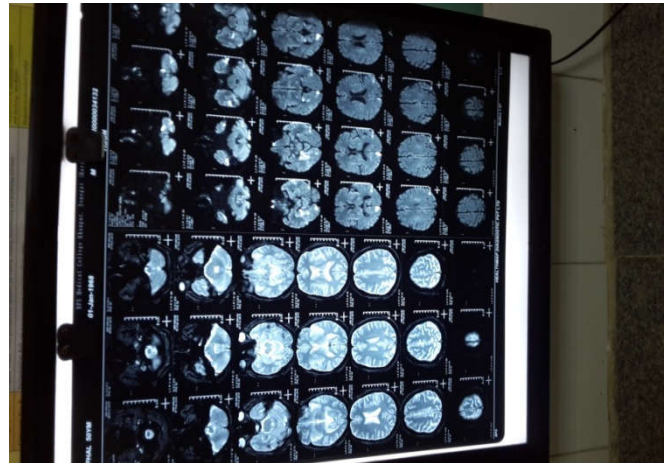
MRI of brain showing hyperintensity on T2 and FLAIR and hypointensity on T1W sequence with diffusion restriction observed in temporo-parietal occipital lobe, left medulla oblongata and left cerebellar hemisphere suggestive of acute infarct.
